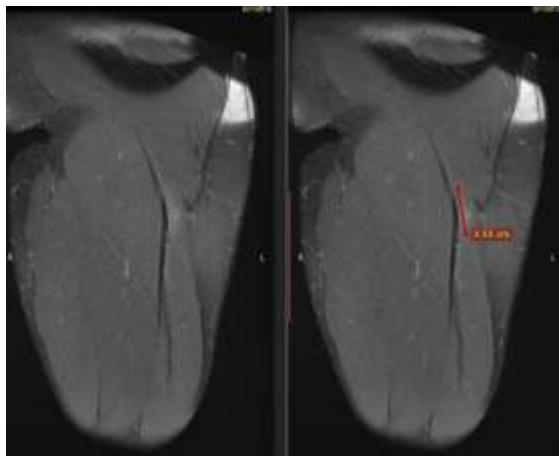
MRI examination.
